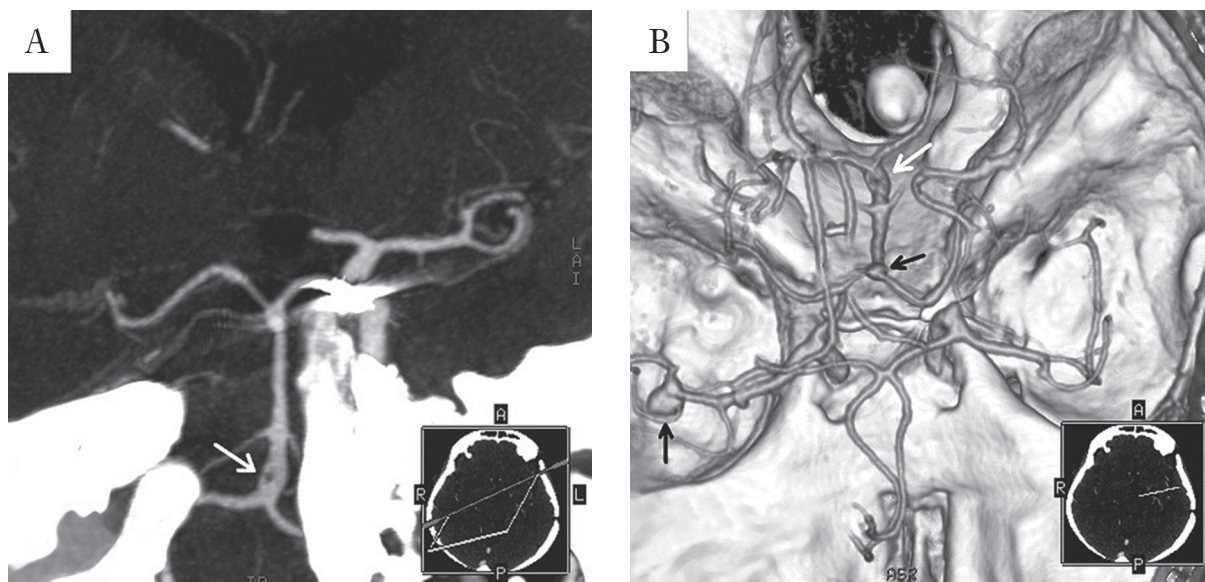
CT angiography – MIP (A) and 3D volume rendering reformats (B). Basilar artery fenestration (white arrow) with coexistence of right middle cerebral artery and basilar artery aneurysm (black arrows). Artifacts after surgical treatment of internal carotid artery aneurysm
